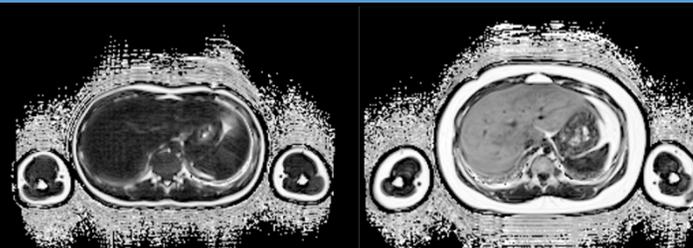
Example MRI images of the liver. (left) 12 year old male, normal BMI-Z, 19% Fat, 1.8% Liver Fat, (Right) 11 year old male, Overweight BMI-Z, 31% Fat, 22.6% Liver Fat.
